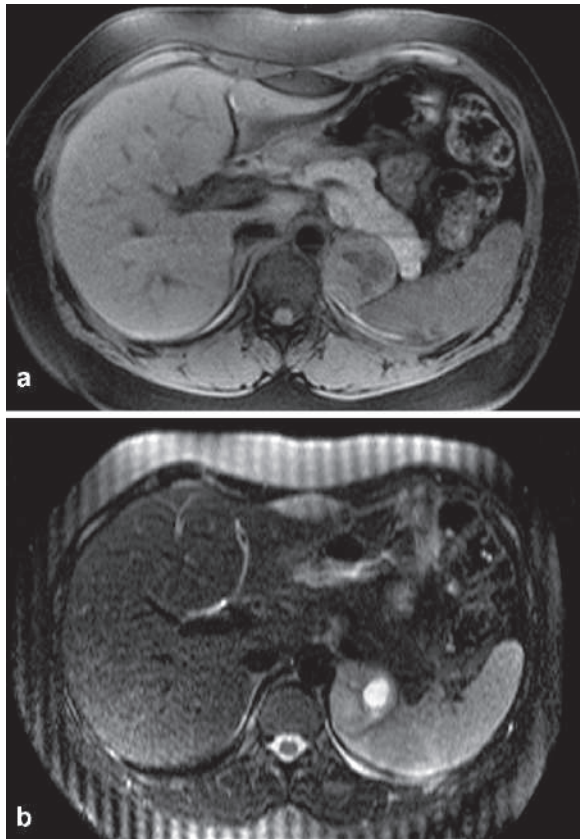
Axial T1W (a) and T2W (b) nonenhanced MRI of a patient with left adrenal pheochromocytoma shows low signal intensity tumor in (a), and the intense T2 signal intensity of the tumor in (b)
